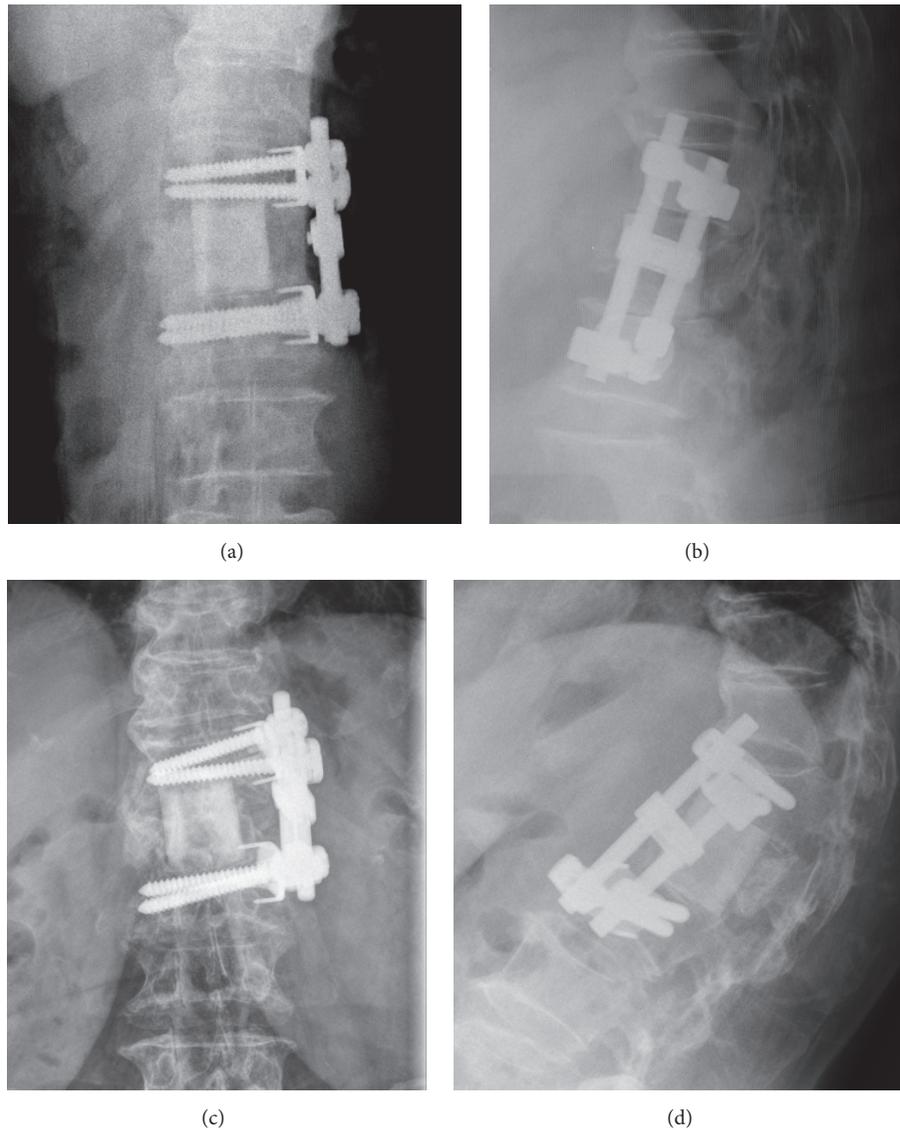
Marked progression of kyphosis of the construct related to loosening of screw fixation and without notable subsidence or penetration of the graft into the adjacent endplate. Preoperative simple radiographs of AP (a) and lateral (b) view and follow-up simple radiograph of AP (c) and lateral view (d) 4 years after surgery.
